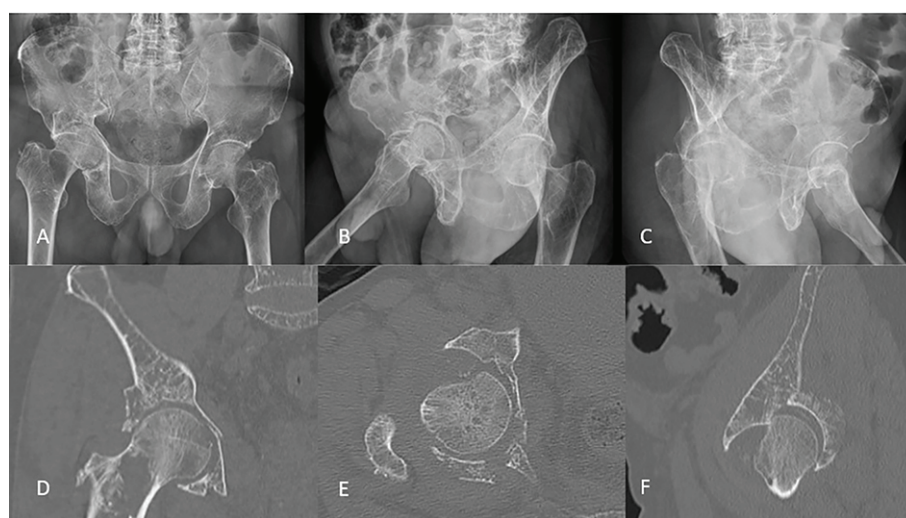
Plain radiographs of the pelvis, AP view (A), iliac oblique view (B), obturator oblique view (C) and CT scan of right hip in coronal plane (D), axial (E) and sagittal (F) shows a right acetabulum fracture with impacted acetabular roof and femoral head, displaced posterior wall and protusio acetabuli
